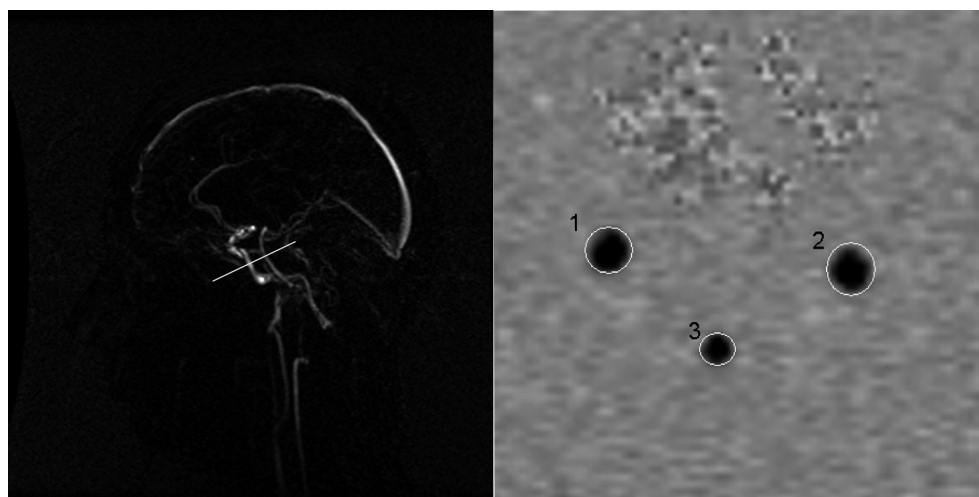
Two-dimensional (2D) phase-contrast MRI flow measurement. (A) Sagittal 2D phase-contrast MRI angiographic scout image for localization of the phase-contrast imaging plane (white line) perpendicular to the carotid and basilar arteries. (B) Two-dimensional phase-contrast MR image (orientation as indicated by the white line in (A)) depicting the carotid arteries (1=right and 2=left) and the basilar artery (3) in black. Manually placed ROIs outline the vessels in white. Note that for improved visualization of vessel boundaries, the contrast between the arteries of interest and the background in (B) is inverted compared with (A).
